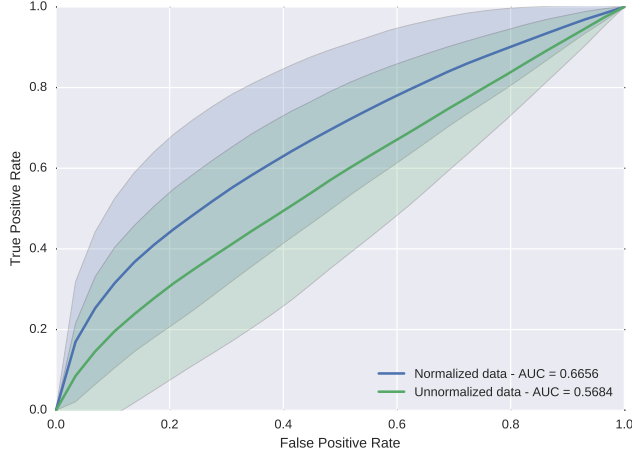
ROC analysis using the entire DCE-MRI signal with and without normalization in conjunction with a RF classifier.
